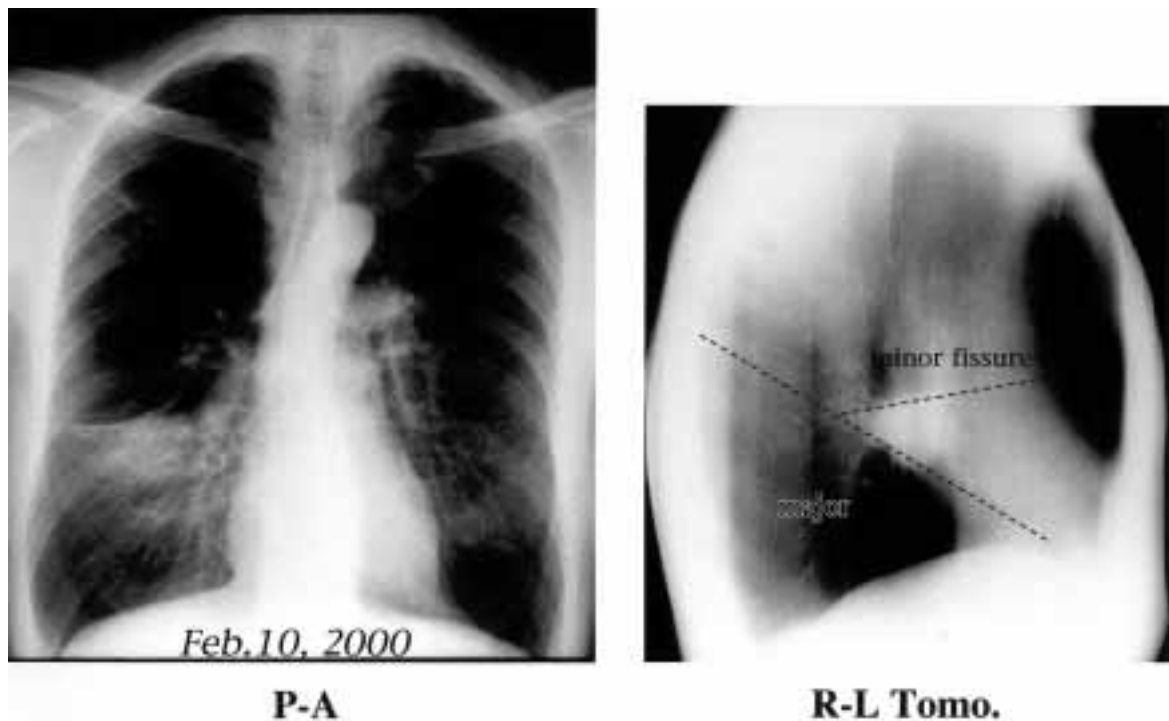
Left: Preoperative plain chest X-ray showed a mass lesion in the middle-lower area of the right lung and bilateral over-inflated lungs. Right: Conventional lateral tomogram showed that the tumor located in the middle of the right lung invaded to both the upper and the lower lobes.
